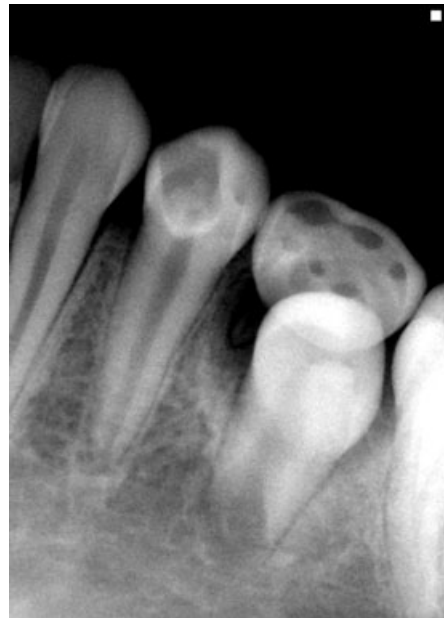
Follow-up periapical radiograph at 11 months showing maturogenesis of the root.
